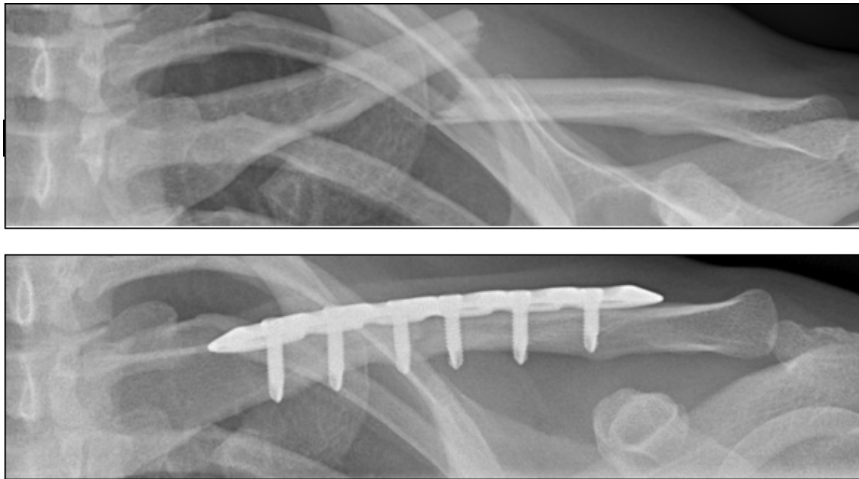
X-ray of left clavicle: A) At the time of the accident, B) 6 months after trauma.
